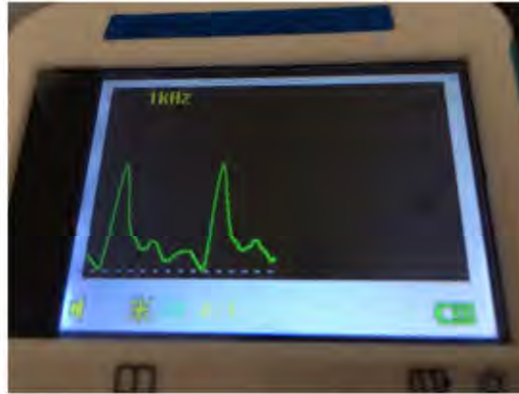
Display of centerline flow velocity profile from the Doppler Ultrasound Scanner
